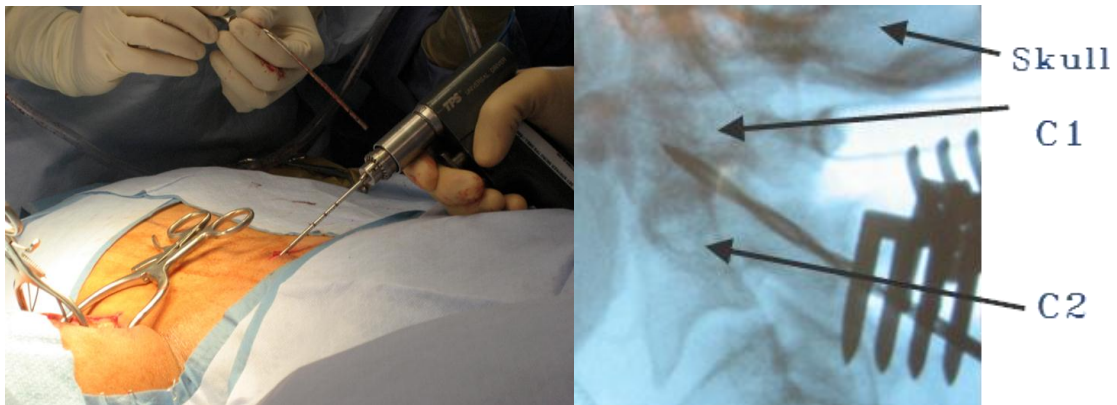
Magerl Surgical Technique. (Left) Surgical drilling of C1-C2 vertebra for transarticular screw placement. (Right) CT scan with drill transecting C1-C2 articulating joint.
